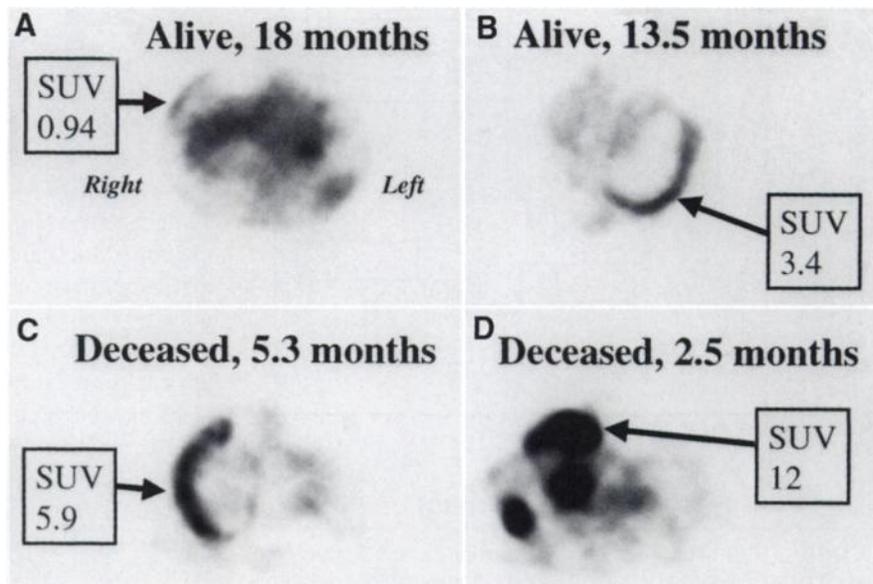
Typical appearance of FDG PET studies in malignant mesothelioma. Transaxial slices were taken from four patients. Patient A, with tumor SUV of 0.94, was alive 18 mo after PET scan. Patient B (SUV 3.4) was alive 13.5 mo after PET. Patients C (SUV 5.9) and D (SUV 12) died shortly after PET scan, at 5.3 and 2.5 mo, respectively.
